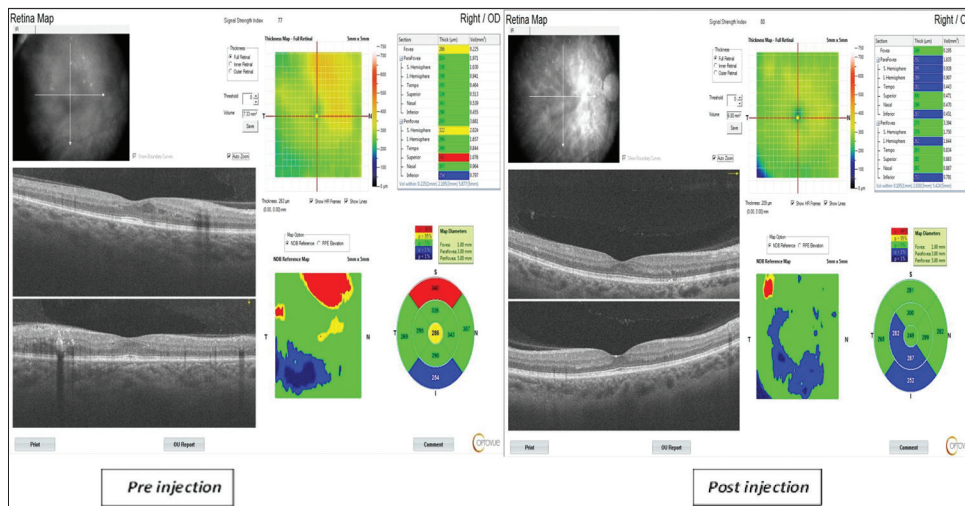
CT of preinjection and postinjection case no. 6. OCT, optical coherence tomography.
